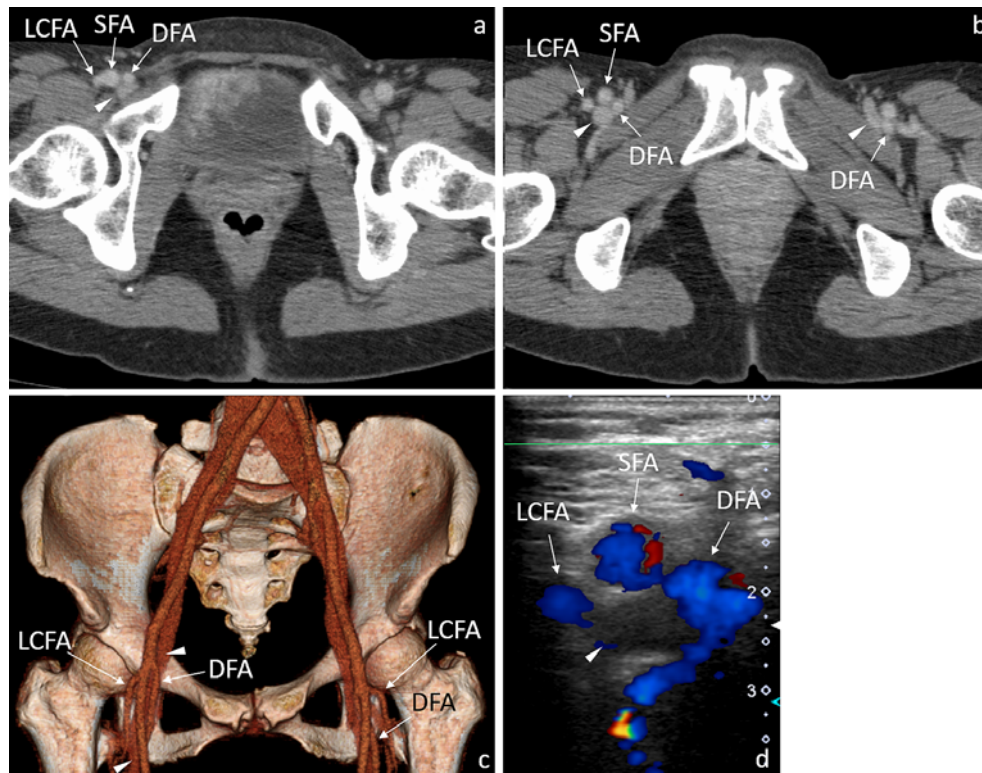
CT (a, b, c) and Doppler ultrasound (d) images of high deep femoral artery (DFA) bifurcation in type 4 (subtype Hc) in a 49-year-old woman. The right DFA bifurcates high running anteromedial to the femoral vein (arrowheads). The right lateral circumflex femoral artery (LCFA) also bifurcates high. The femoral vein (arrowheads) is surrounded by these arteries, including the superficial femoral artery (SFA). The left femoral approach was selected.
